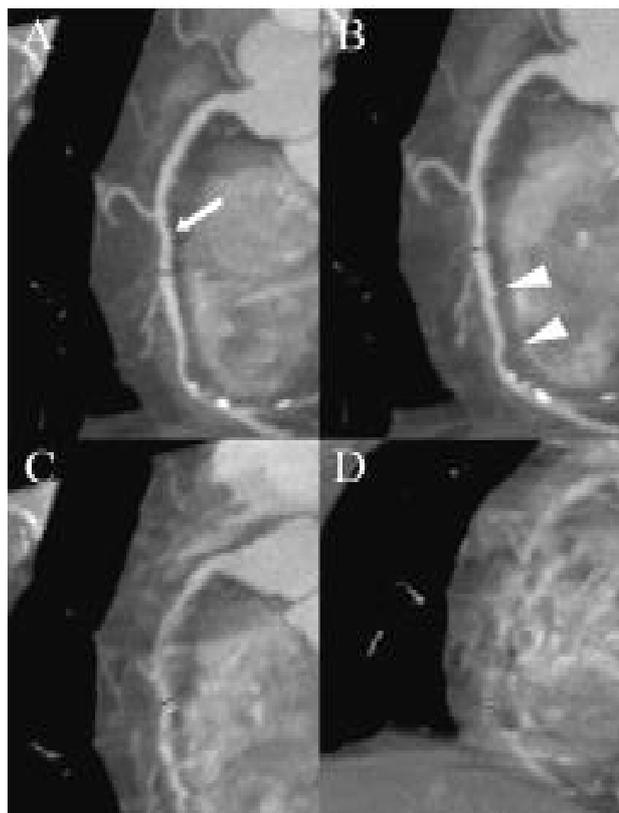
Image quality scoring on maximum intensity projection images of multislice computed tomography coronary angiography using a five-point scale A – well-defined contours (image quality score of 1) are observed in the proximal segment of the vessel, while the middle and distal portions of the same artery show minor stepwise artefacts (image quality score of 2) (arrow); B – moderate stepwise artefacts (image quality score of 3) (arrowheads); C – severe motion artefacts (image quality score of 4); D – the vessel structure is not evaluable (image quality score of 5).
